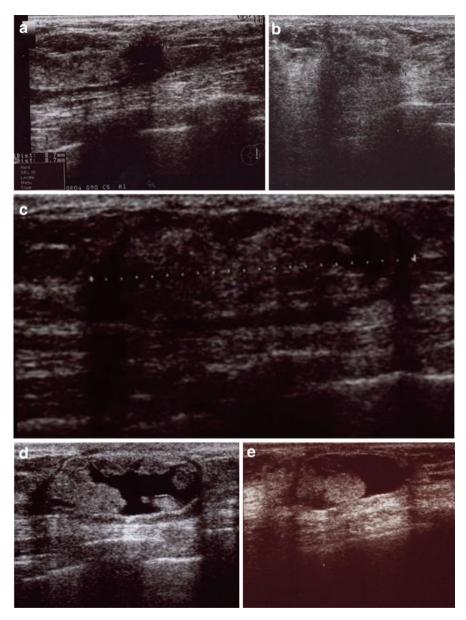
(a) Representative preoperative ultrasonography (US) demonstrating an 8×8 mm-sized hypoechoic mass without intraductal extension. (b) US performed 1 month after radiofrequency ablation (RFA) demonstrating a 20×15 mm-sized hypoechoic lesion with an unclear boundary. (c) US obtained 1 year after RFA. The boundary of the ablation zone is recognized as a mass with a hypoechoic belt. (d) US performed 2 years after RFA. The ablation zone is showed as a 20×10 mm-sized cystic and solid tumor. (e) US performed 5 years after RFA. The ablation zone is reduced, and increases in the internal hypoechoic region and the circular solid mass with clear boundaries can be observed as lateral shadows
